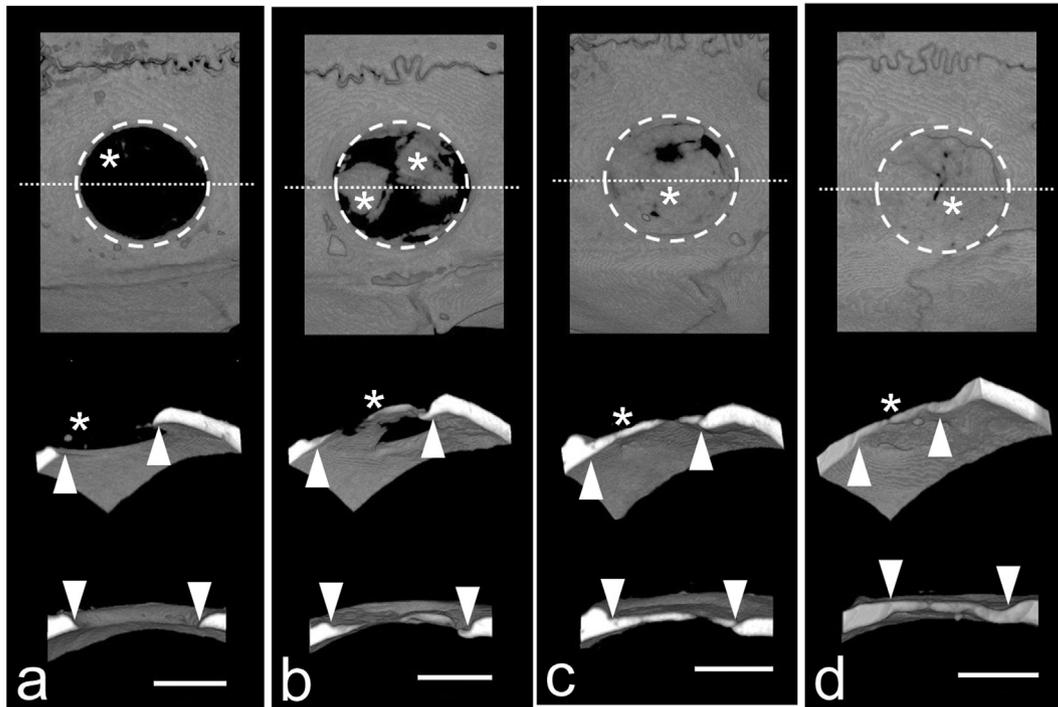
Micro-computed tomography images of bone healing in weeks 1 (a), 2 (b), 4 (c), and 8 (d). The upper images are elevated views of the defect area (dashed circle) from the skin side. The images of the defect area were sectioned along the midline (dashed line), as shown in the middle and lower images. The middle images are views from the dura mater side, and the lower images are views of the mid-plane of the defect area. The periphery of the defect is indicated with arrowheads. Scale bars = 2000 μm * Adapted from Okata et al. (2015) [52]. With permission from John Wiley & Sons Ltd.
